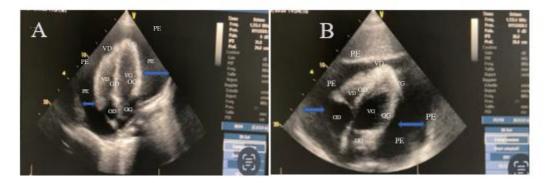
(A) Transthoracic 2-dimensional echocardiogram (apical view) showing a large pericardial effusion (arrow) and of the right atrium. (B) Transthoracic 2-dimensional echocardiogram (subcostal view) showing large pericardial effusion (PE)
